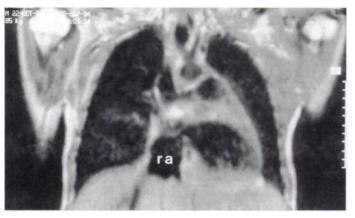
Coronal MR image. ra = right atrium.
